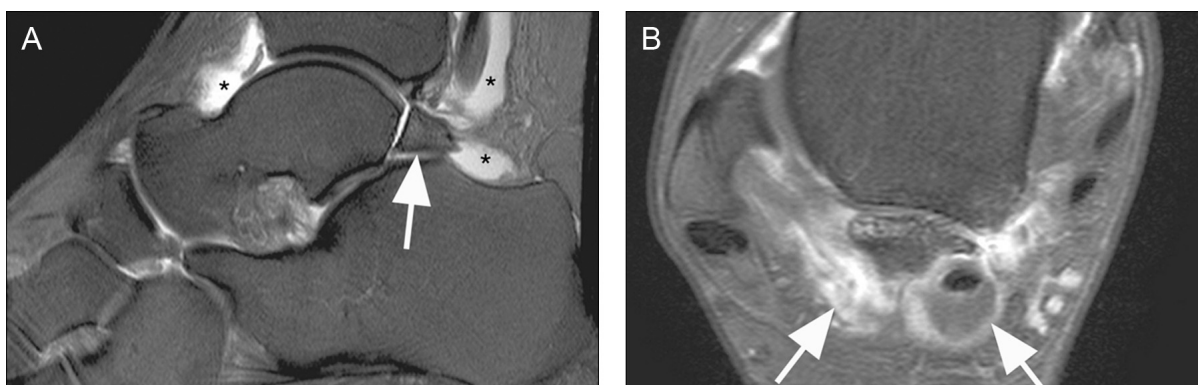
A 46-year-old female active runner with chronic posterior pain suggesting posterior impingement syndrome. (A) Sagittal proton density-weighted fat-suppressed MRI shows an os trigonum (arrow) and marked synovitis and effusion posteriorly, anteriorly and around the flexor tendons (*). (B) Axial contrast-enhanced T1-weighted fat-suppressed MRI superiorly differentiates the synovial thickening from fluid (arrow). In this case the inflammation was due to diffuse synovitis of the ankle in recently diagnosed rheumatoid arthritis. Note almost normal signal within the os trigonum.
